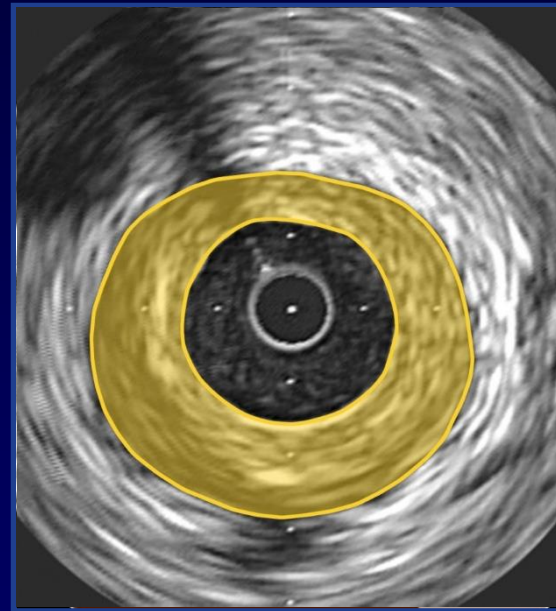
Images courtesy of Cleveland Clinic Intravascular Ultrasound Core Laboratory
